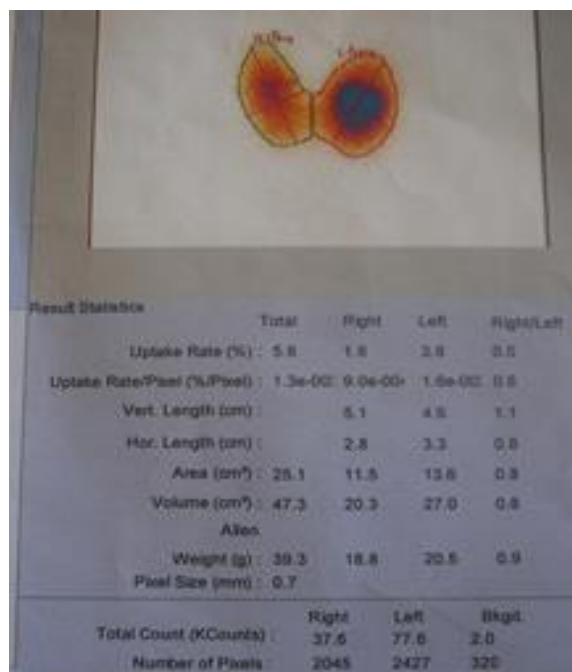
99mTc thyroid scintigraphy reveals a "hot" nodule in the left thyroid lobe and a suppressed right lobe with high total uptake.
